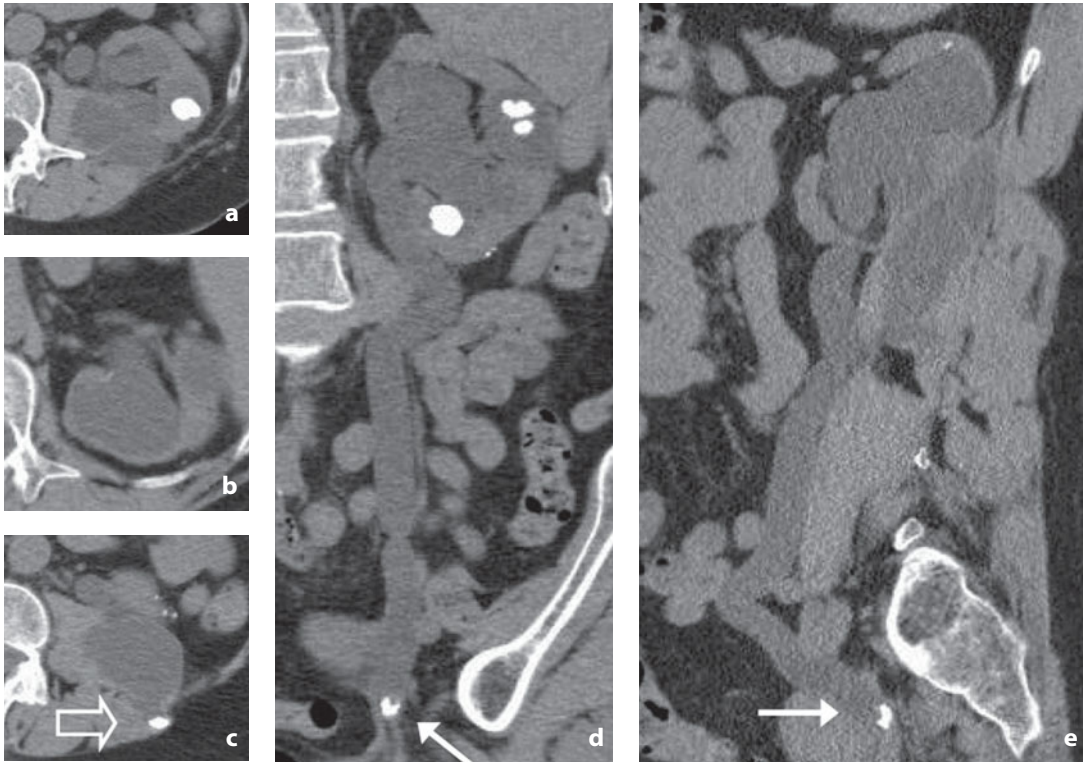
Nonenhanced CT. Complicated lithiasis (patient with left renal colic and fever). a-c Native axial and coronal (d) and sagittal (e) multiplanar reformation (MPR) images. The images show stones in the calices with significant dilatation of the intrarenal cavity and markedly thinned parenchyma. The ureter appears dilated up to the pelvic segment where a stone formation is evident (*arrow*). A voluminous fluid collection is also visible in the iliopsoas muscle associated with the migrated stone (*open arrow*)
